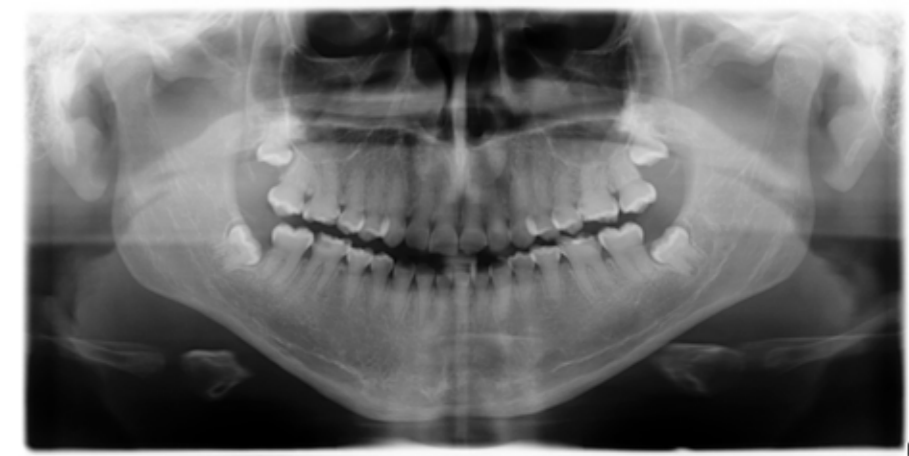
Orthopantomogram of the preoperative situation: The relatively short tooth roots and the obliterated pulp chambers are clearly visible.
